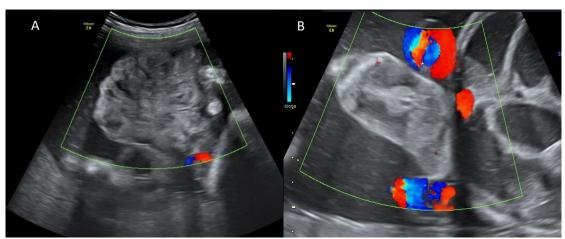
Prenatal ultrasound findings
